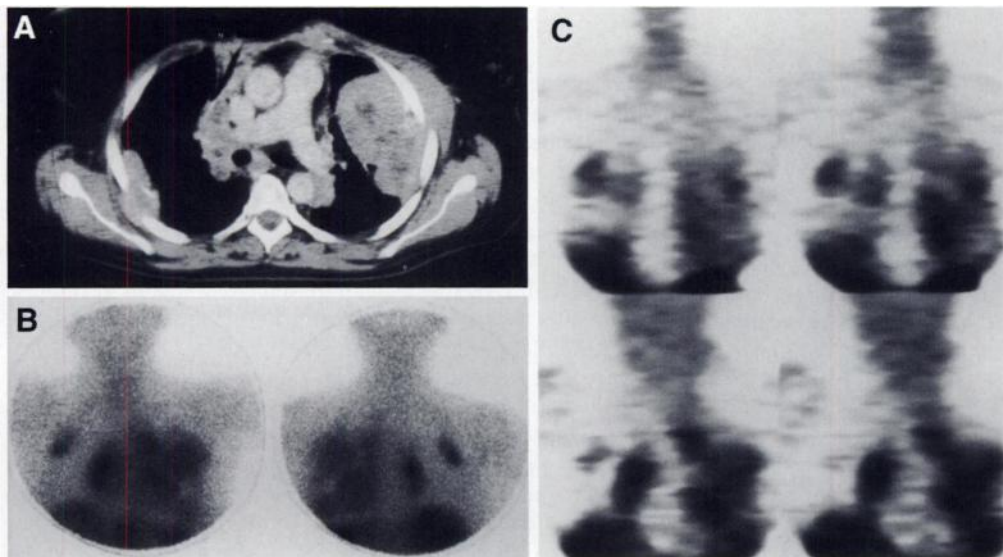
(A) Multiple bilateral pulmonary and pleural thymoma metastases are clearly detected by anterior and posterior views 24 hr postinjection. (B) The CT slices confirm the sites of disease documented by SRS. (C) Coronal tomographic slices acquired at 24 hr.
